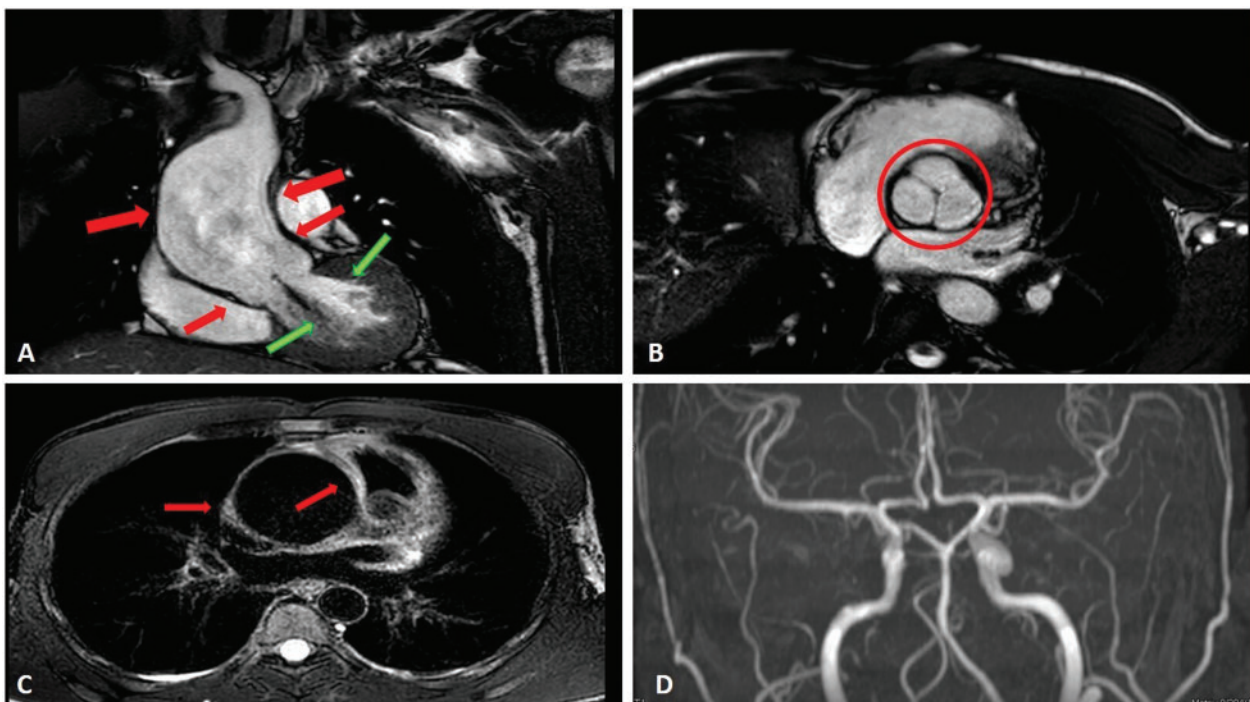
Magnetic resonance imaging. (A) Bulbar ectasia (44 mm, inferior red arrows), supravalvular ascending aortic aneurysm (64 mm, superior red arrows), and mild aortic regurgitation (regurgitant fraction 29%, green arrows); (B) normal tricuspid aortic valve (red circle); (C) thickening of the ascending aortic wall (~5 mm, red arrows), in the absence of oedema or signs of dissection; (D) normal intracranial arterial vessels.
